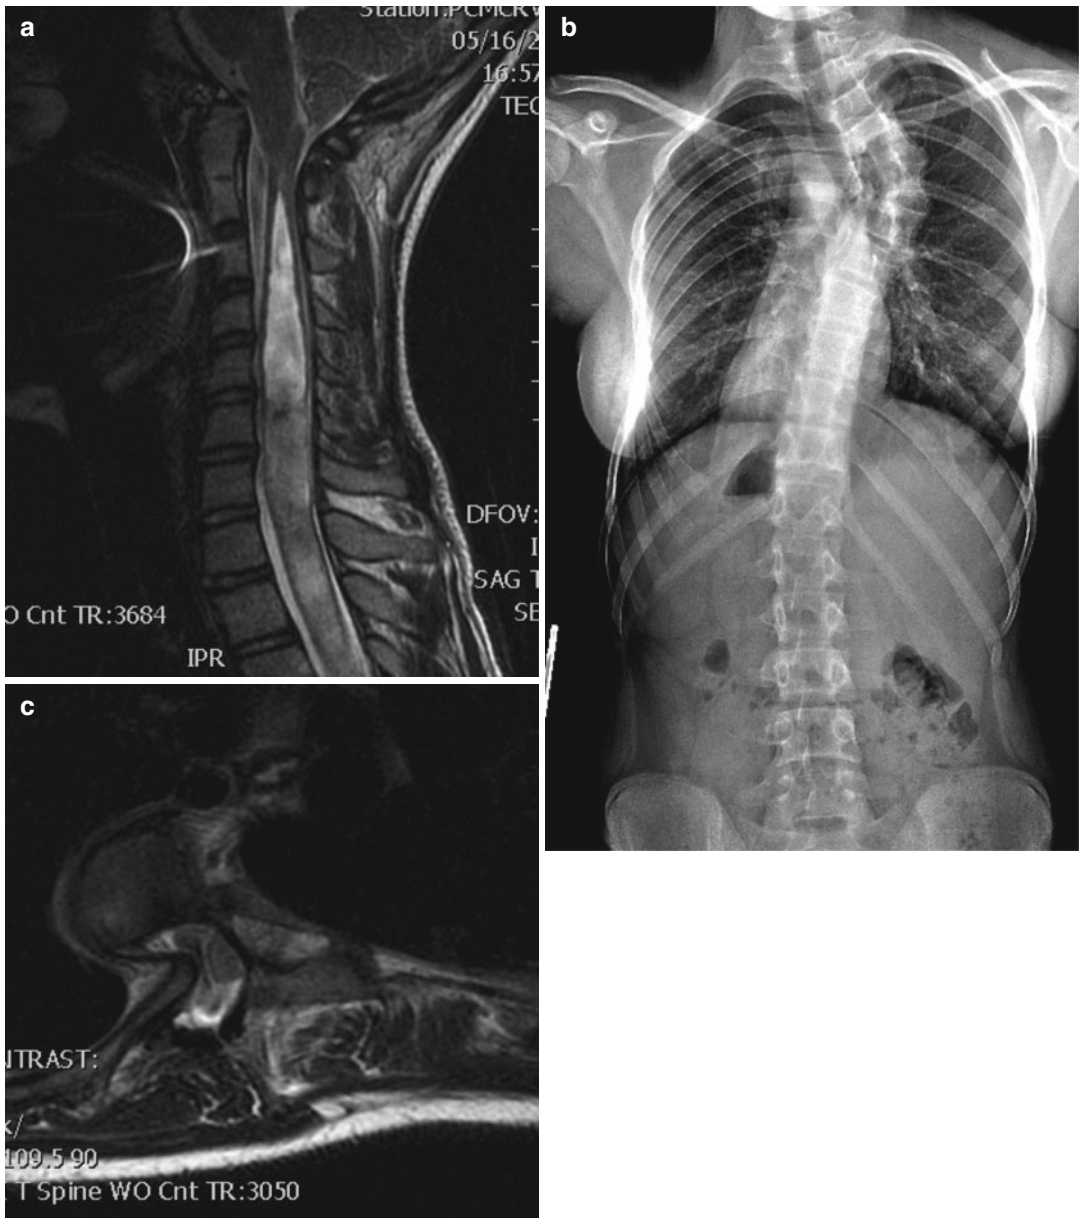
(a) MRI is an important screening tool to look for associated malformations of the spinal cord. This figure demonstrates a Chiari malformation and associated Syringa. (b) Plain radiograph of a 14-year-old female with neurofibromatosis, Type 1. It was not evident that she had
